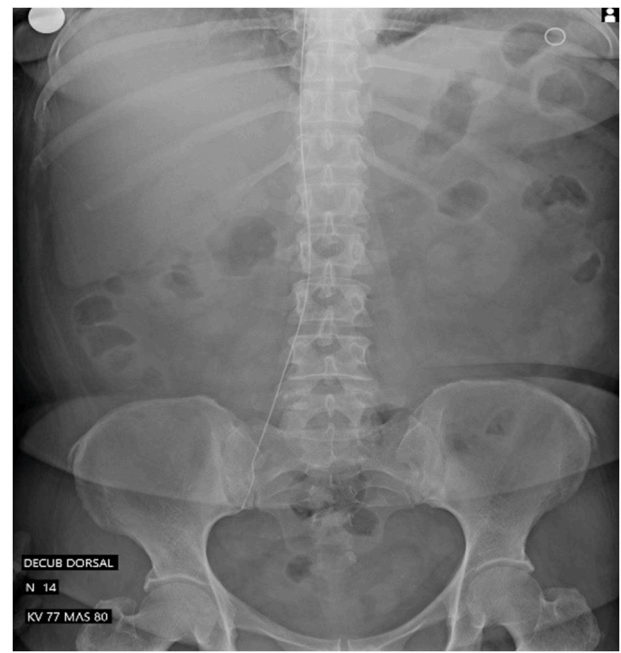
Abdominal X-ray showing a guidewire with proximal end in the topography of the right iliac venous axis, and shaft ascending in the topography of the inferior vena cava.
